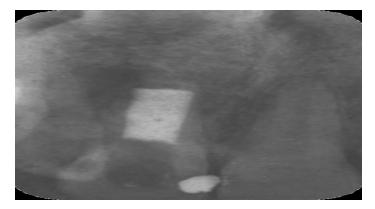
Root canal filling Radiography.
